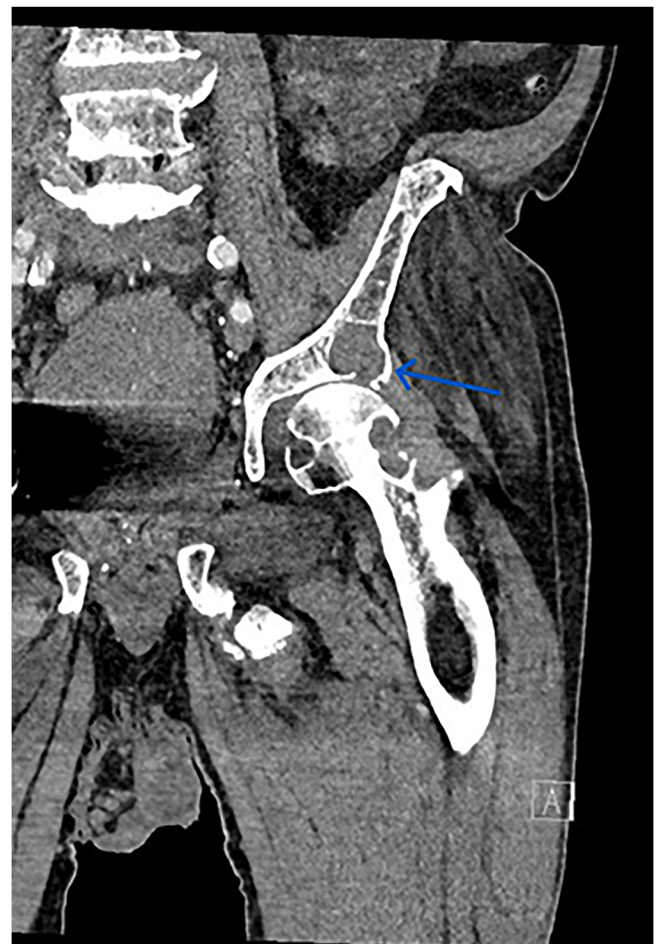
Coronal computed tomography of left hip demonstrating left hip joint space narrowing with subperiosteal bone resorption and cystic changes of superior acetabulum (arrow) as well as femoral neck and head.
